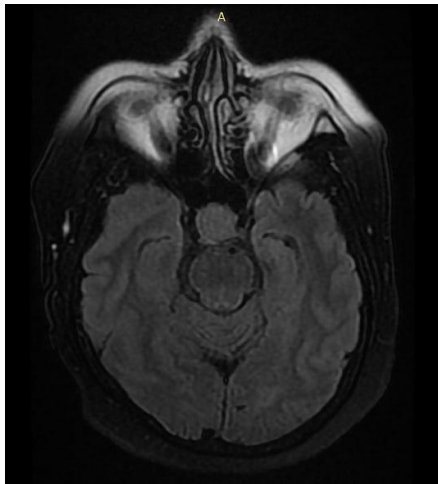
MRI – signs of cystic formation in the sellar region. Cystic adenoma of the pituitary gland. An empty Turkish saddle. Vascular encephalopathy. Indirect signs of intracranial hypertension. Subatrophic processes of the cerebral hemispheres
